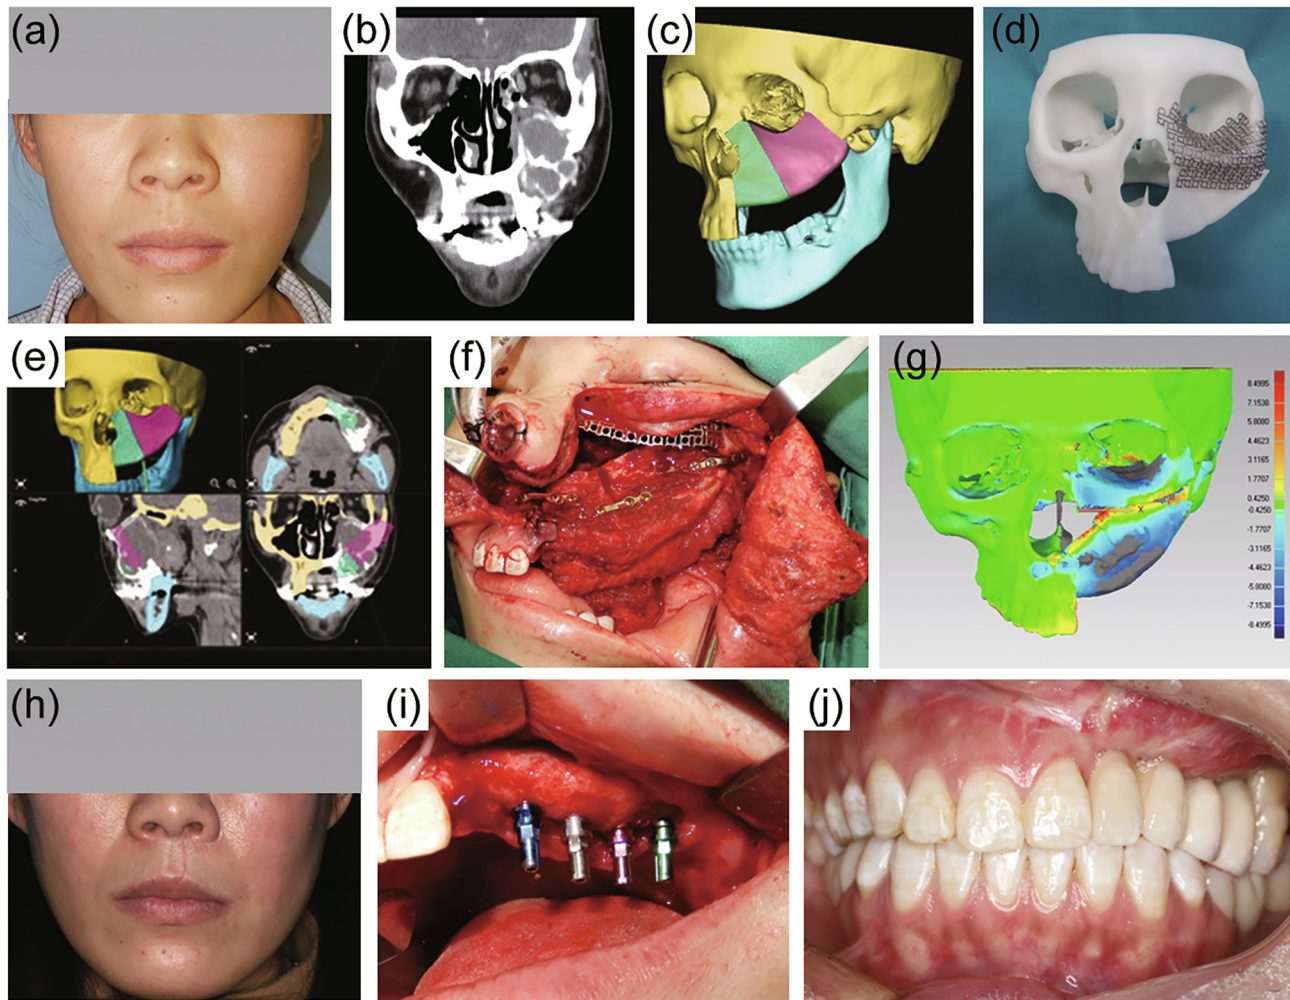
A female patient diagnosed with myxoma. (a) Preoperative facial appearance. (b) CT showing osteolytic destruction of the left maxilla which involved the floor of the orbit. (c) Computer-assisted virtual planning included tumor resection with total maxillectomy and iliac bone free flap reconstruction. (d) 3D stereomodel was printed based on the computer-assisted design and a patient-specific titanium mesh was performed on the model for the floor of the orbit reconstruction. (e) The surgery was performed under the assistance of computer-assisted navigation system. (f) The maxillary defect was repaired with an iliac bone flap and the preformed mesh. (g) Color map of pre- and post-operative (1 year after surgery) maxilla model showed good consistency between virtual planning and actual surgery. (h) The facial symmetry was satisfactory at 1 year after surgery. (i) Dental implants were placed after the correct iliac bone flap healing at 2.5 years after surgery. (j) Postoperative intraoral view after dental prostheses were finished at 3 years after surgery.
